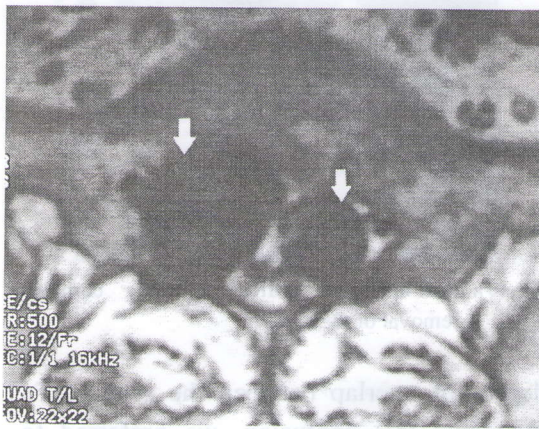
MRI axial veiw showed bilateral sacral perineural cysts.
